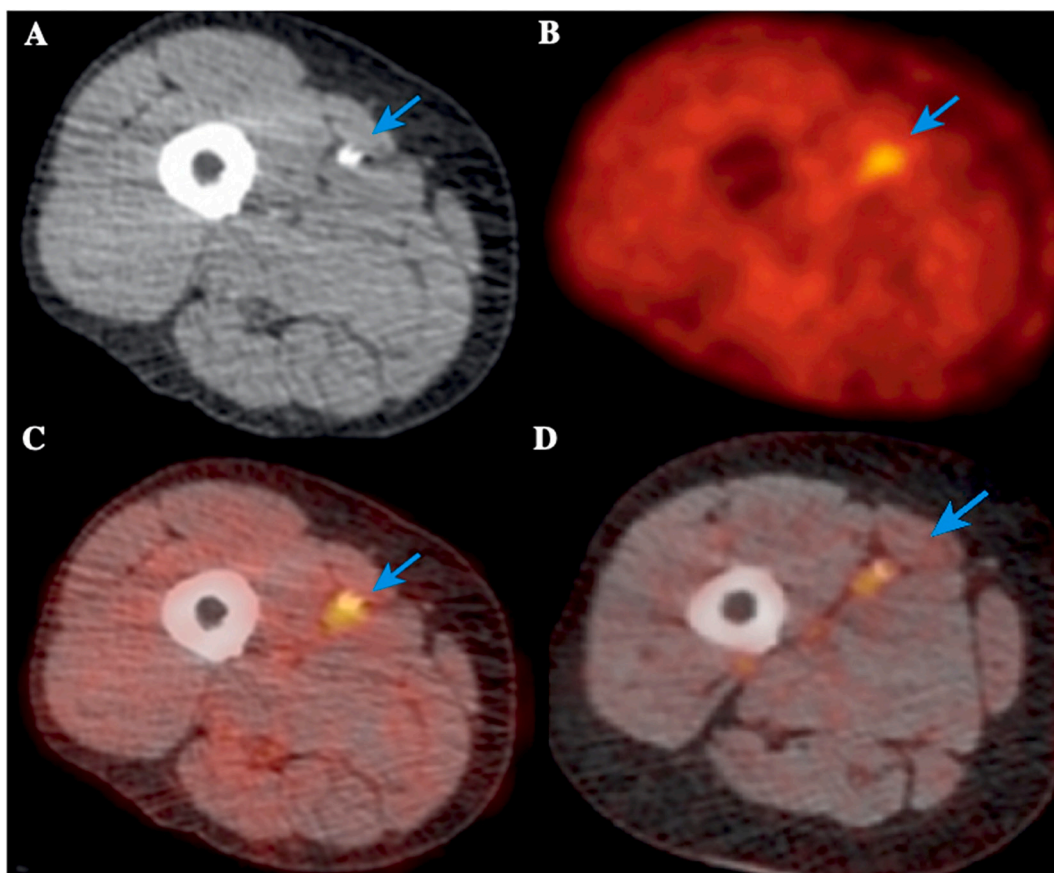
Early Efforts Have Shown the Potential of PET Imaging to Predict Outcomes in Vascular Disease. Chowdhury et al. Evaluated Patients With Peripheral Artery Disease (PAD) Before and 6 Weeks After Angioplasty. Patients with Signal Uptake (Blue Arrow) Denoted at Baseline in the Non-contrast CT (Fig. A), 18F-FDG PET (Fig. B), and Fused 18F-NaF PET/CT (Fig. C), that Persisted 6 weeks after Angioplasty (Fig. D), Was Significantly Associated with Restenosis of the Vessel at 1-Year. Figure adapted from Chowdhury et al. *J Am Coll Cardiol Img.* 2020 Apr, 13 (4) 1008–1017. (For interpretation of the references to colour in this figure legend, the reader is referred to the web version of this article.)
